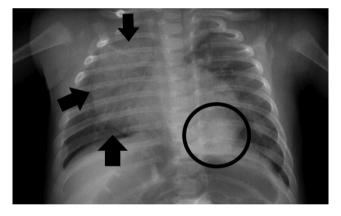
Chest radiograph at the time of first admission shows rounded density in the left lower lobe. Thymus gland is taking place in the right superior and midlle zone (shown with arrows)
